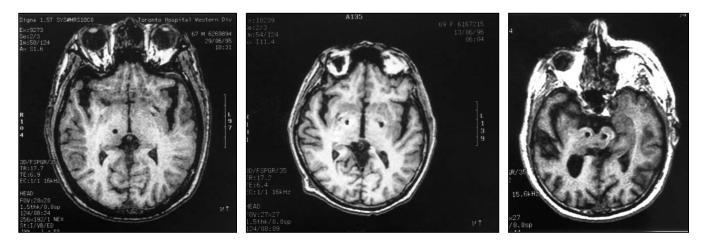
T1 weighted MRI images of patients with unilateral VIm DBS electrode (left), bilateral GPi electrodes (centre) and bilateral STN electrodes (right).
